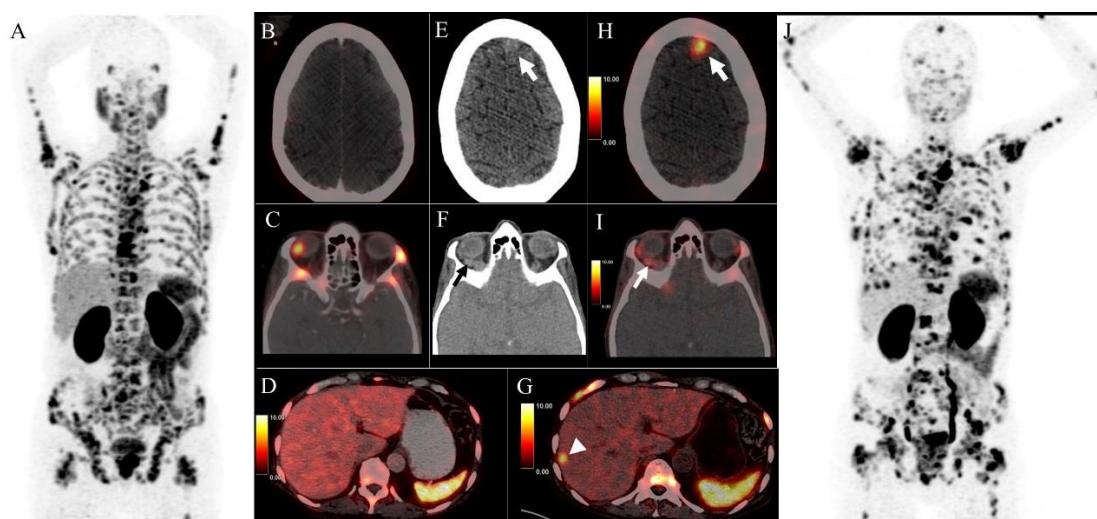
^{68}Ga -PSMA-HBED-CC PET/CT performed after initial two cycles of ^{225}Ac -PSMA therapy for response assessment (A) showing tracer avid lesions in the prostate and multiple skeletal metastases (without any visceral lesions; B, C, D). ^{68}Ga -PSMA PET/CT performed after completion of a total of 4 cycles of ^{225}Ac -PSMA therapy showing extensive tracer avid skeletal lesions and interval appearance of new lesions in the brain, involving the left frontal cortex (E, H – thick arrow), soft tissue lesion in the right retro-ocular location (F, I – thin arrow) and the segment VII of liver (G, arrow-head) with overall scan representing disease progression (J)
